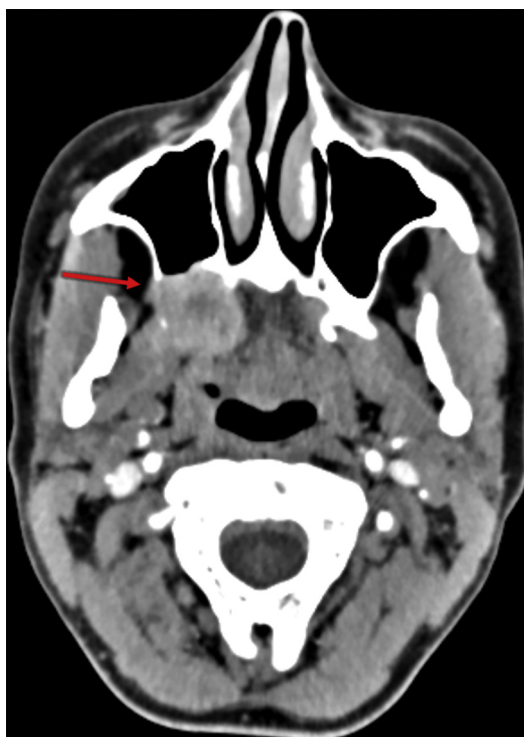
Right palatal minor salivary gland neoplasm, adenocarcinoma, which initially presented with facial numbness in a 49-year-old woman. Axial image shows a right palate mass eroding the posterior right maxillary sinus and adjacent pterygoid plates (arrow). Incidental aerodigestive lesions can occasionally be identified on emergent stroke evaluation (CT angiogram, as shown, or MR imaging of the brain).
